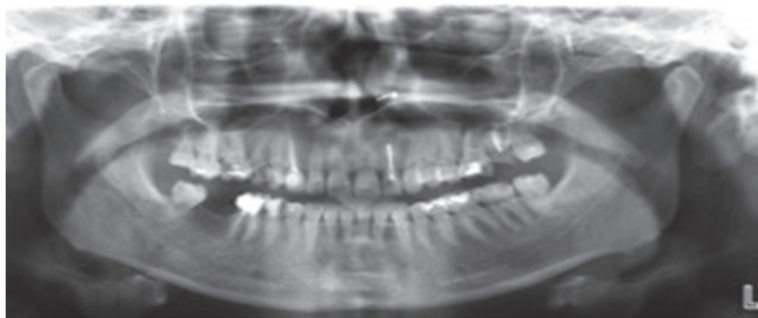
Orthopantomogram (Kovaľová et al., 2005)
